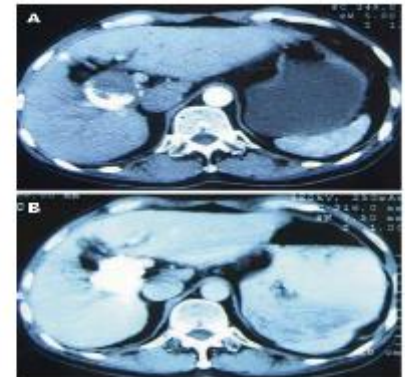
The following para-toluenesulfonamide injections resulted in a significantly improved clinical prognosis. A: Contrast computer tomography (CT) after the first 5 para-toluenesulfonamide (PTS) injections demonstrated a decreased nodule with partial retention of lipid. Enhancement necrosis and no blood supply were found in the real part of the tumor; B: Two months after the last 3 PTS injections, contrast CT revealed homogeneous dense retention of lipid within the entire tumor nodule and no enhancement was identified.
